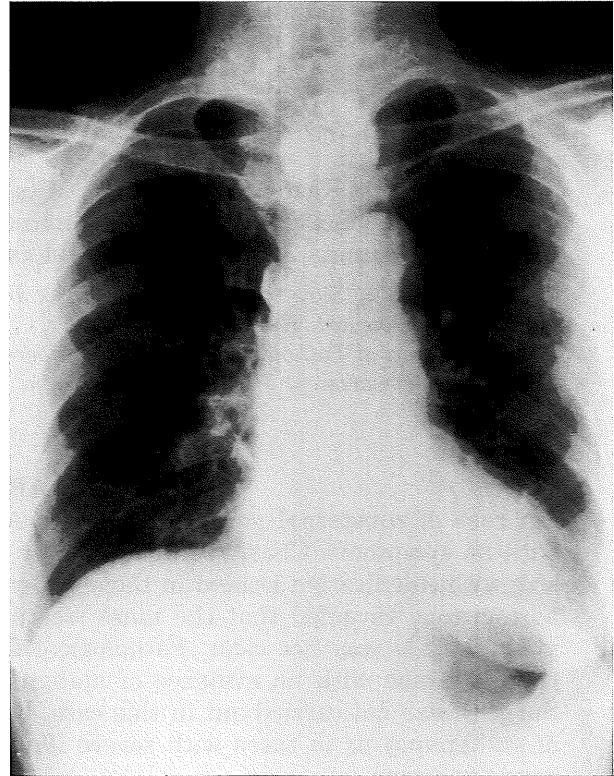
Chest X-ray on admission revealed that the trachea was displaced by the the mass at the upper mediastinum. The tumor size had not changed in comparison with the findings of one year before.
